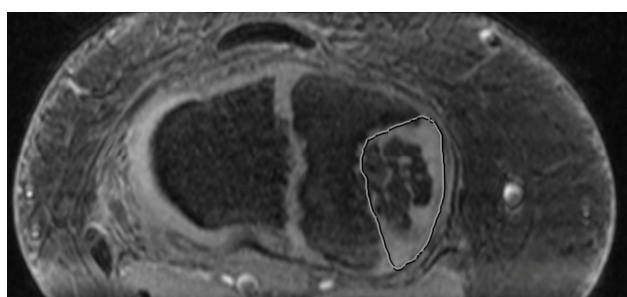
Orthogonal axial MRI 3-D reconstruction of disrupted proximal tibial physis in a patient with infantile Blount disease. For the purposes of this study, bar size was calculated as percentage surface area of the entire affected physis (white outline).
